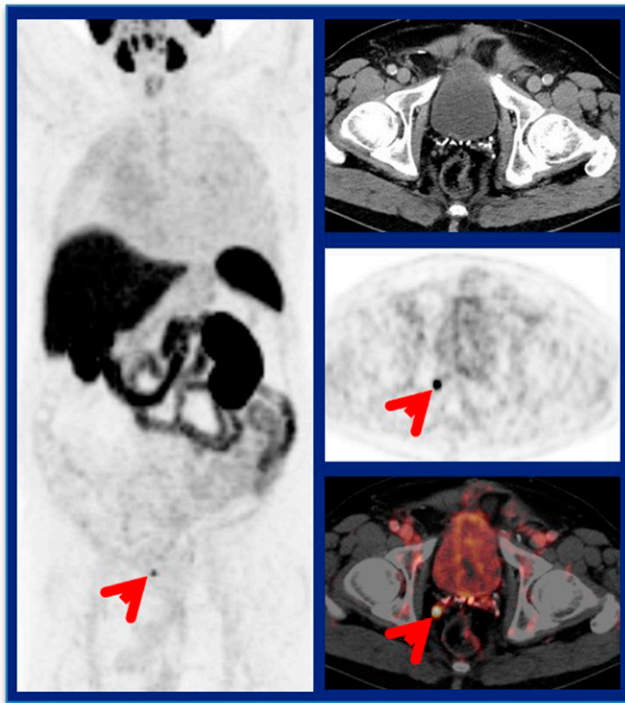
^{18}F -rhPSMA-7 PET for detection of biochemical recurrence of prostate cancer following radical prostatectomy. The study included 532 patients with noncastrate biochemical recurrence after initial prostatectomy, with an initial prostate-specific antigen (PSA) average of 0.97 ng/mL (range, 0.01–372 ng/mL). Image shows a 78-year-old man (pT3a, pNO, Gleason score 8, and PSA = 0.35 ng/mL) who had pelvic disease identified on PSMA PET (arrow), not detected on pre-study CT scan. The ability to detect lesions was found to be highly dependent on PSA range.
